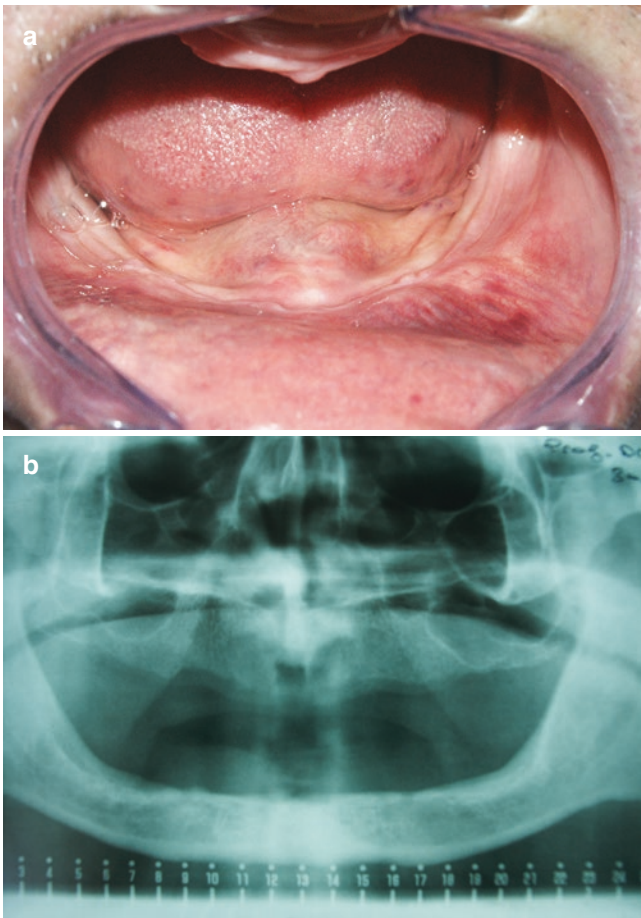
(a) Ridge resorption up to the mental foramen. (b) Panoramic X-ray image
